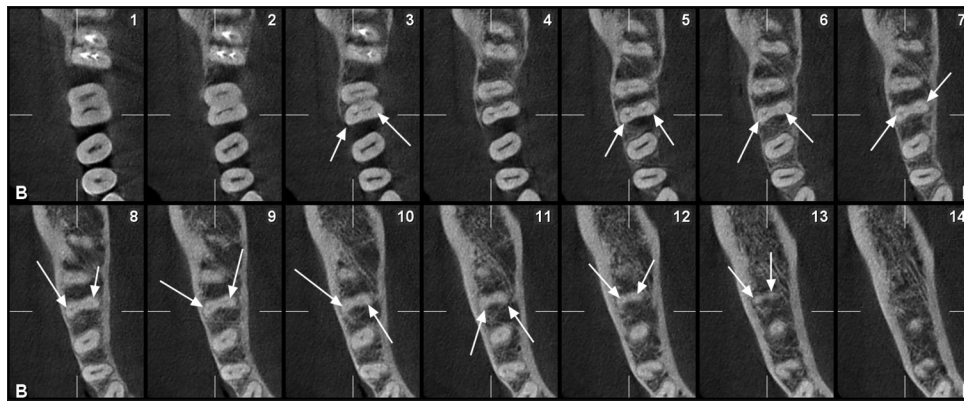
Axial cone-beam computed tomography sections of the mandibular first molar. Arrows denote the canals of the mesial root
